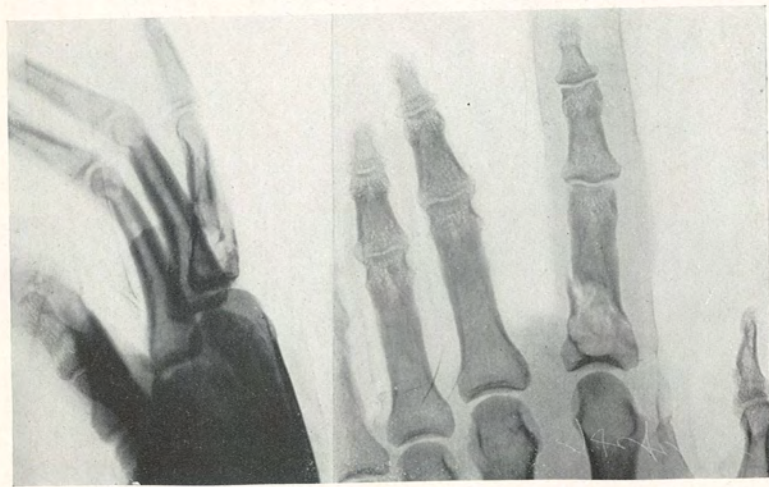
Radiograph in Case III. Fracture at site of cyst in base of proximal phalanx of index finger.
